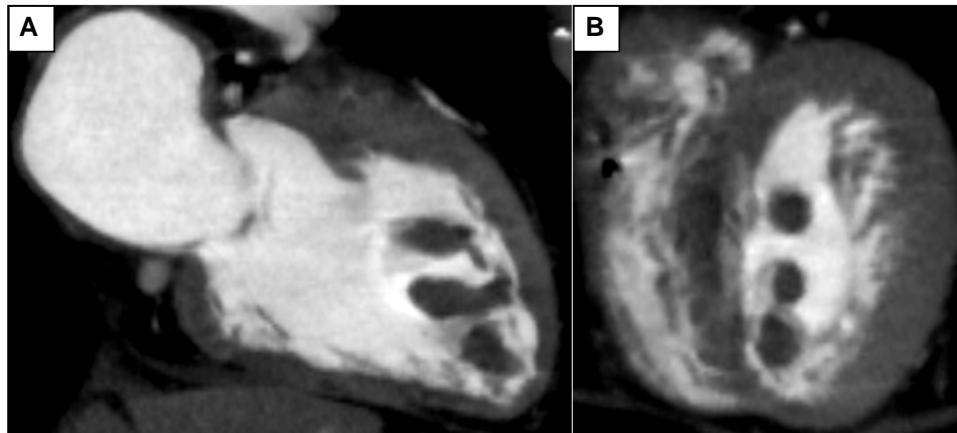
Computed tomography showed multi-thrombi in the left ventricle. (A) Long-axis view. (B) Short-axis view.
